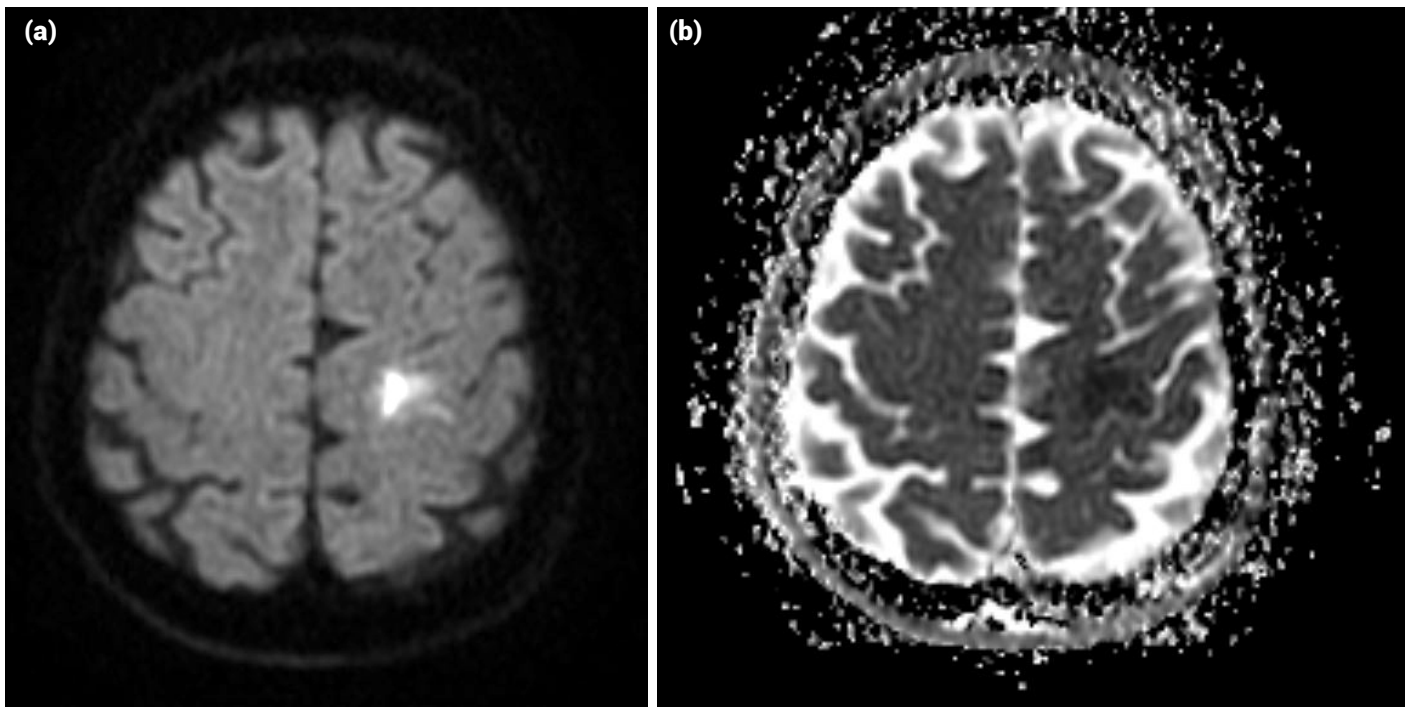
Left middle cerebral artery infarction on diffusion-weighted magnetic resonance imaging.
